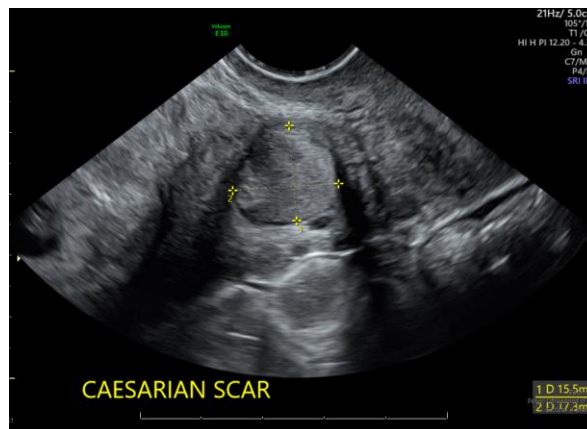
Transvaginal Ultrasound. Caesarean scar lesion measuring 16x12x17mm. Lesion becoming less cystic and more solid.
